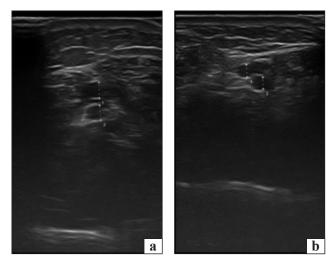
A 16-year-old patient V., diagnosis: cerebral palsy, hemiparetic form with reflex tonic muscle tension of the right lower limb. Doppler imaging of the posterior tibial vein: a — left lower limb (1D — 0.34; 2D — 0.31); b — right lower limb (1D — 0.26; 2D — 0.24)
